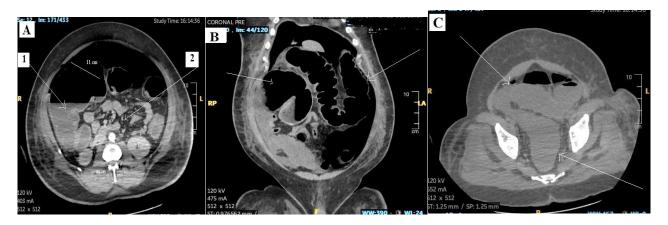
(A-C): Abdomen CT scan showing entire colon distension. Distended colon (1) with ascending colon diameter of 11 cm and collapsed small bowel (2). Coronal view showing distended colon (both arrows) and distended sigmoid colon and entire rectum (both arrows).
